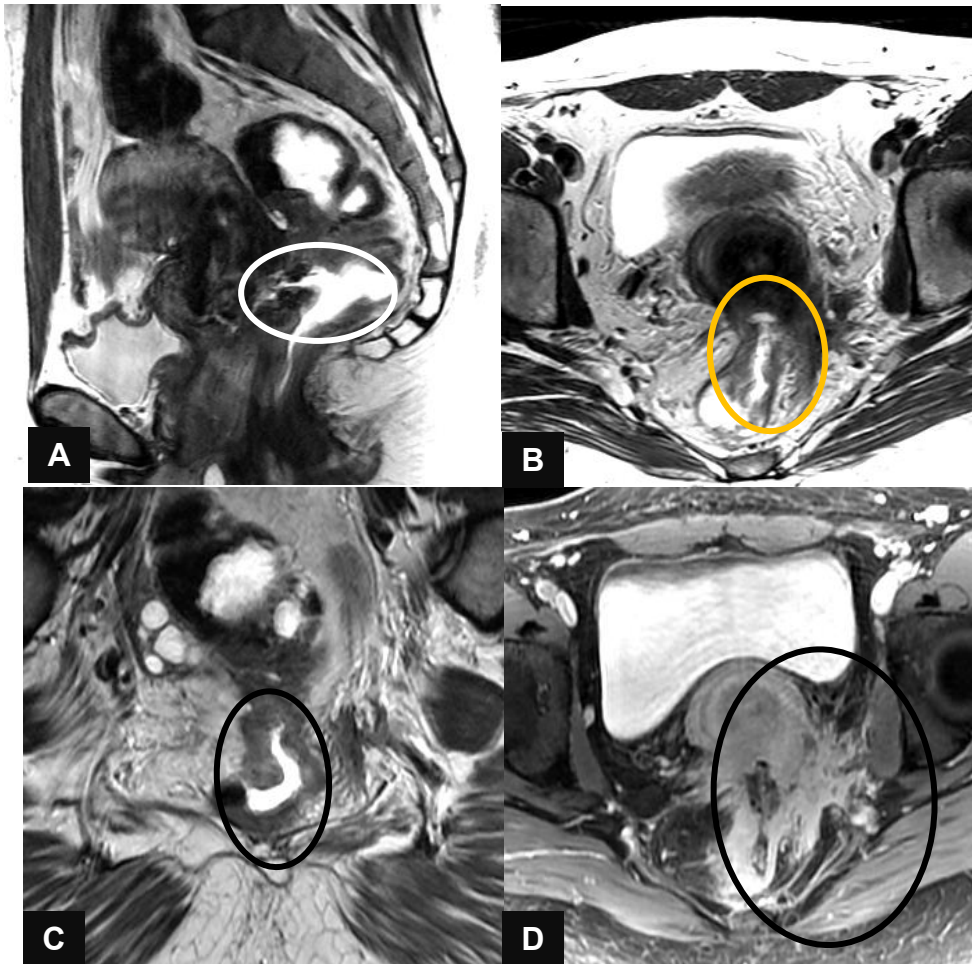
30-year-old female with known anal-rectal cancer. 3.0T MRI demonstrates Stage 4 carcinoma with a rectal-vaginal fistula. (A) Sagittal T2W. (B) Axial T2W. (C) Coronal T2W image demonstrating tumor involvement. (D) Postcontrast, the tumor is shown to extend beyond the left border through the mesorectal fascia into the vagina, extending into the left sciatic notch.
